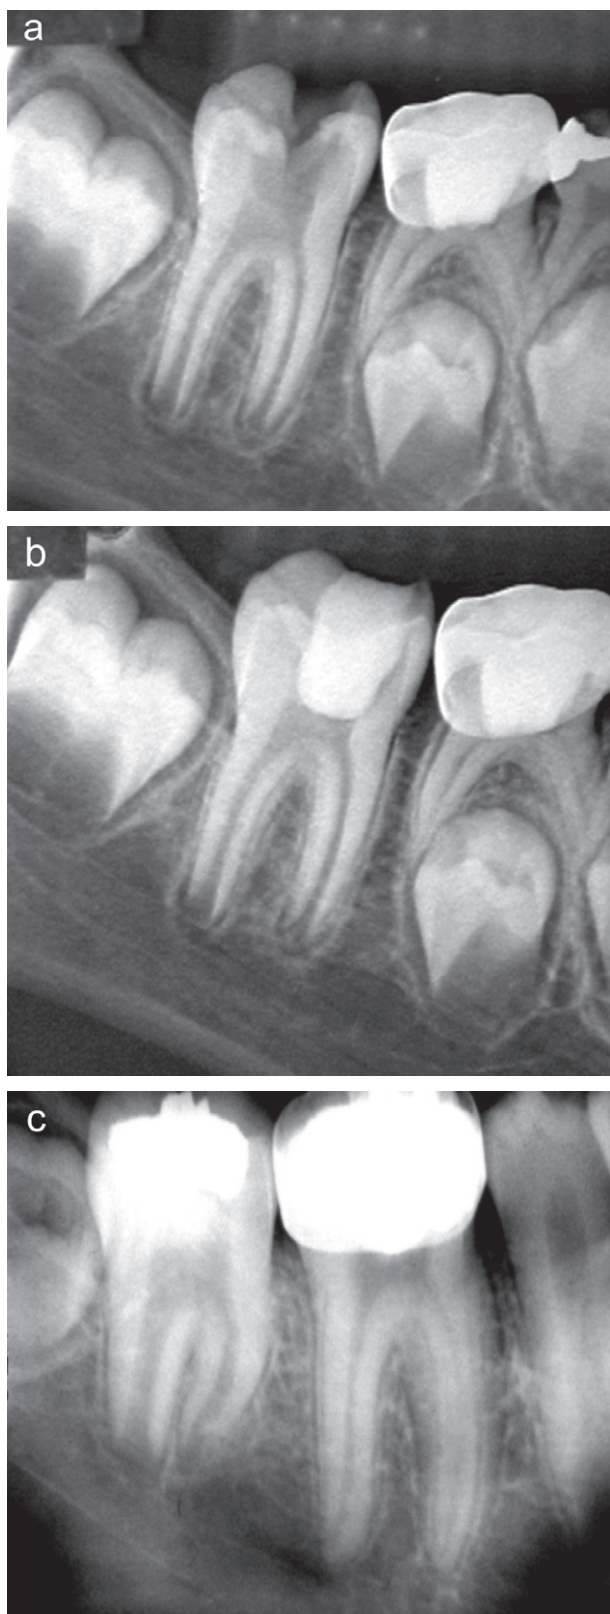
(a) Pre-operative radiograph reveals the presence of extensive decay, immature roots, and open apices in the first mandibular molar. (b) After removing the decay, the pulp exposures were capped with MTA and the tooth was restored with amalgam. (c) Radiographic examination of the patient 4 years later shows the development of roots and continued apical closure of the root apices in this tooth. The tooth is asymptomatic and responds to cold.
